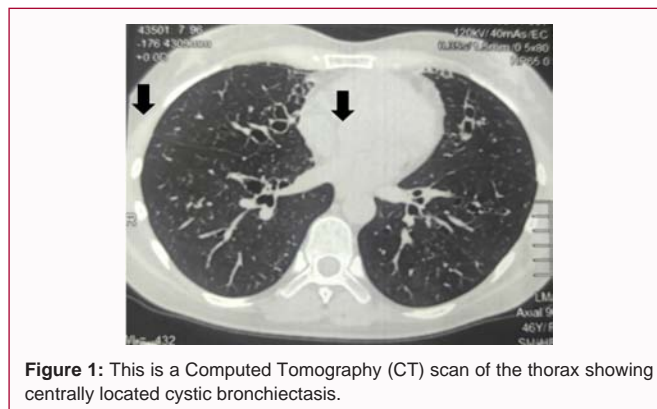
This is a Computed Tomography (CT) scan of the thorax showing centrally located cystic bronchiectasis.
